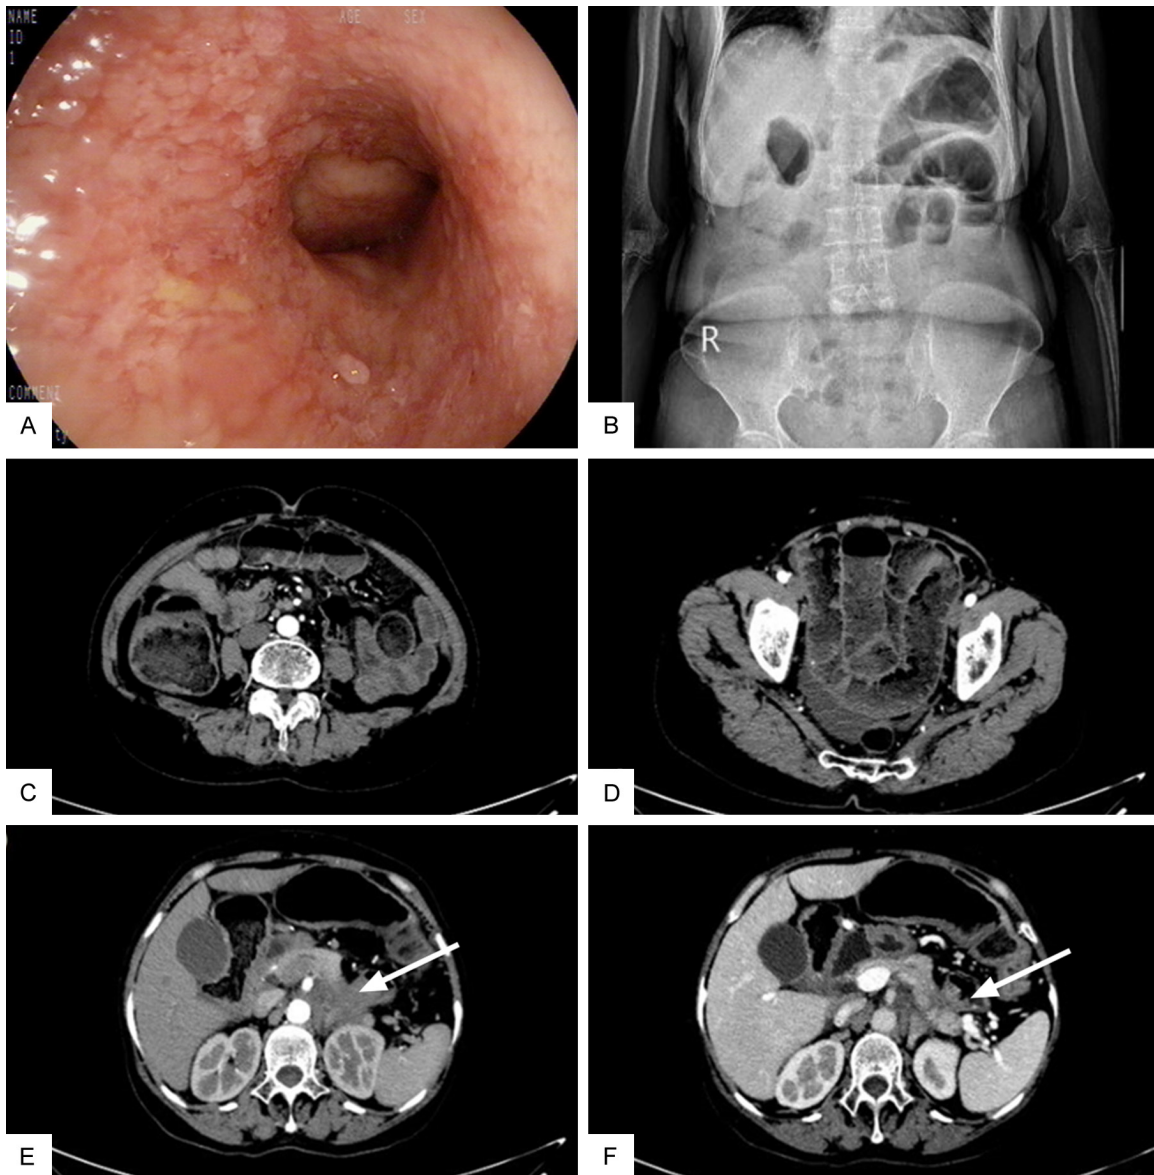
Endoscopic and radiological manifestations of the patient. (A) Colonoscopy revealed congestion and edema of the descending colonic mucosa with marked luminal narrowing. (B) An upright abdominal radiograph revealed dilated bowel loops with air-fluid levels. (C-F) Abdominal computed tomography (CT) revealed dilated bowel loops with air-fluid levels (A-D). Bowel wall thickening was observed in the proximal descending colon, and a mass (white arrow) was detected in the pancreatic body and tail.
